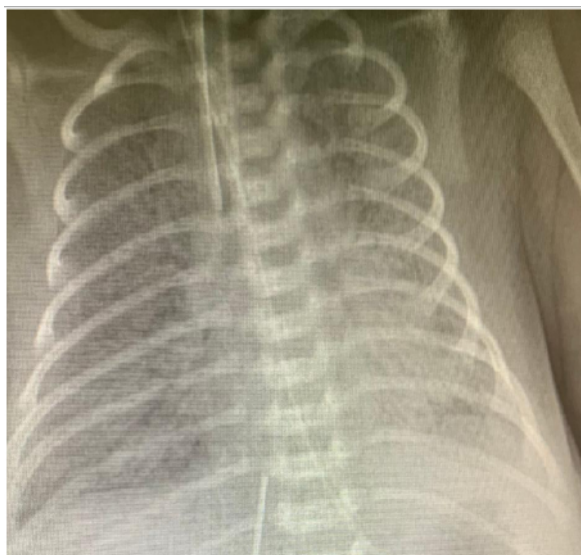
Chest x-ray. High frequency ventilation + nitric oxide + lung recruitment maneuver. Day 8
